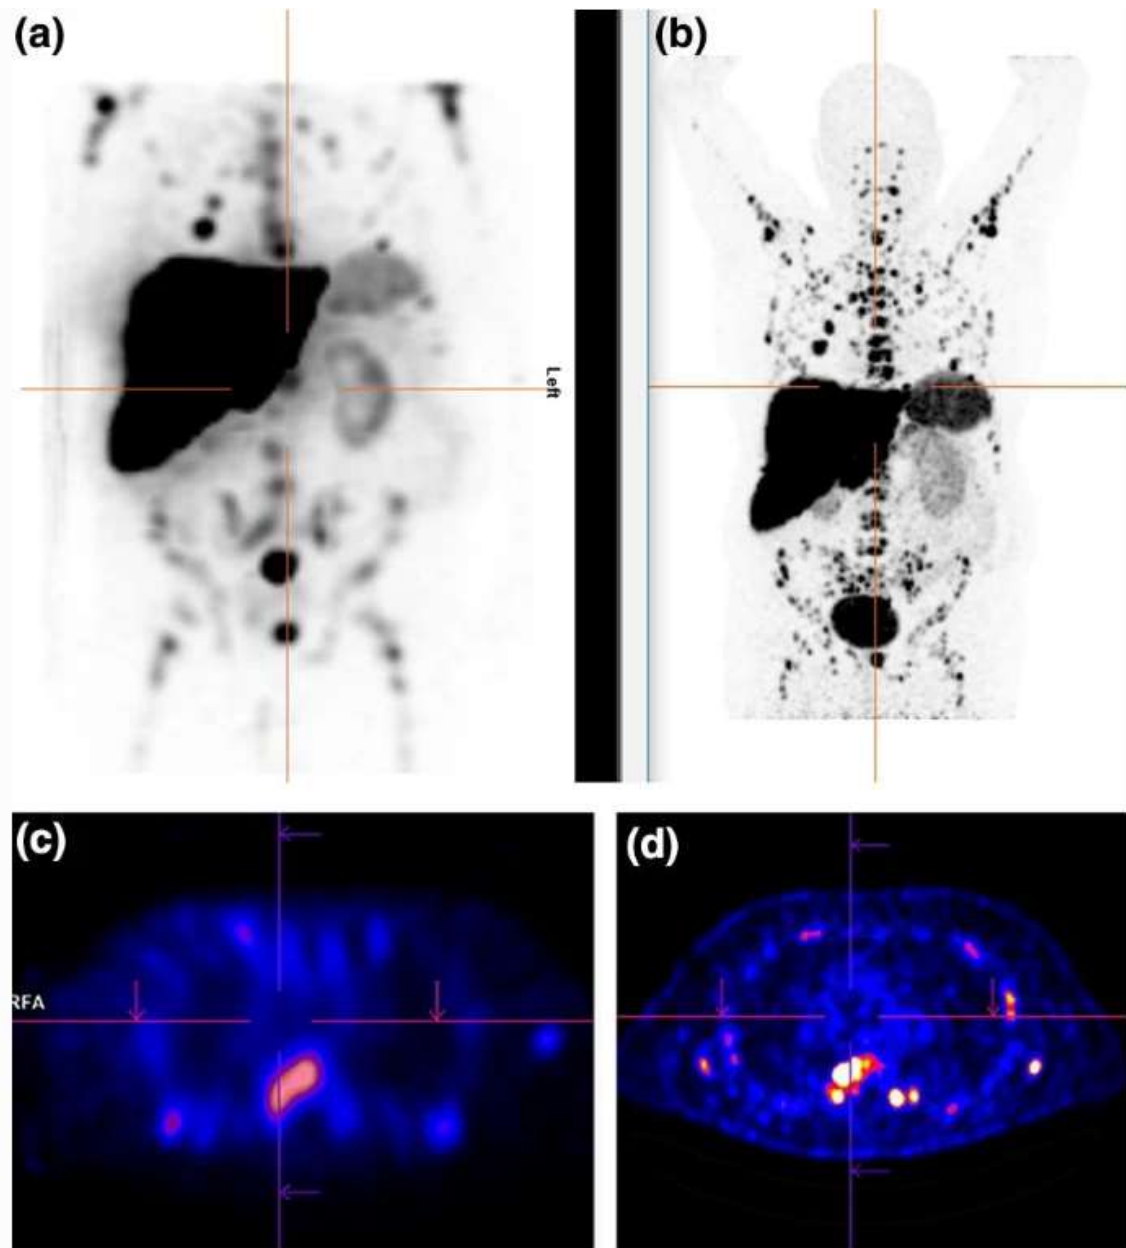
(a) ^{177}Lu -somatostatin analogue – maximum intensity projection (MIP) image of a 61-year-old male patient and (b) 3 months later follow-up with ^{64}Cu -DOTATOC PET-CT MIP images showing metastasized NET (grade 1) Transaxial images with ^{177}Lu -somatostatin analogue (c) and 3 months later follow-up with ^{64}Cu -DOTATOC PET-CT (d) (Mirzaei et al., 2020).
